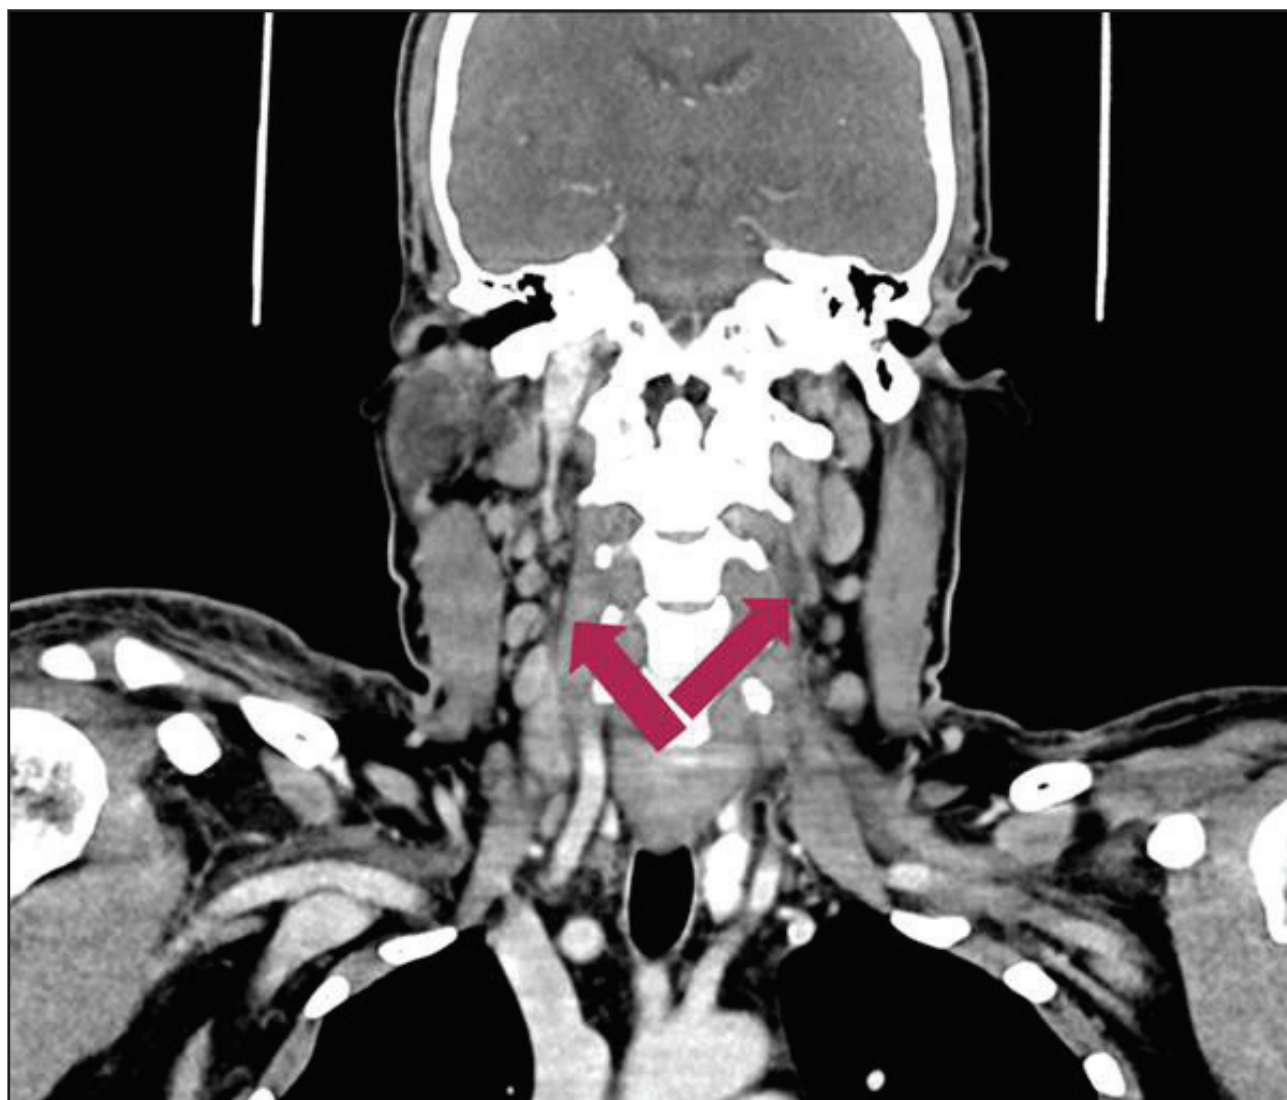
Contrast-enhanced CT neck demonstrating bilateral cervical lymphadenopathy, asymmetric tonsillar prominence, and a small left tonsillar fluid collection, supporting acute tonsillitis or upper-airway inflammation as a diagnostic distractor and possible infectious trigger, without evidence of critical airway narrowing.
